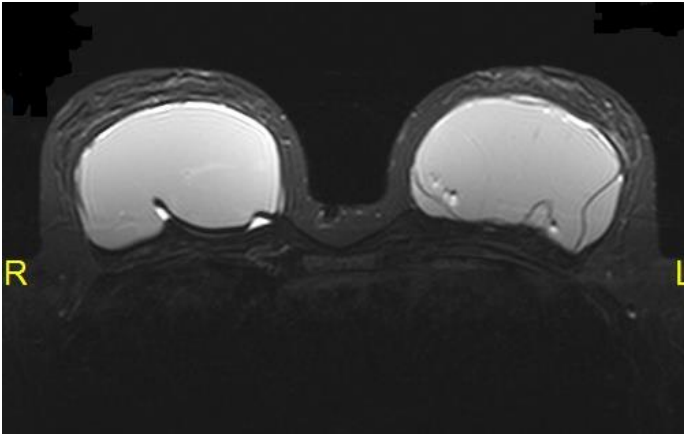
Water-suppressed STIR-T2-weighted axial image of both breasts shows infolding of an intact implant in the right breast. Shell rupture and partial collapse of the implant in the left
